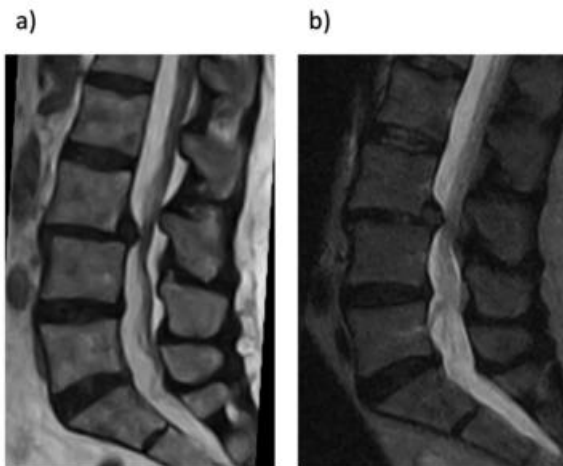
Sagittal MRI in clinostasis (a) and orthostasis (b) position in patient with spinal stenosis.
